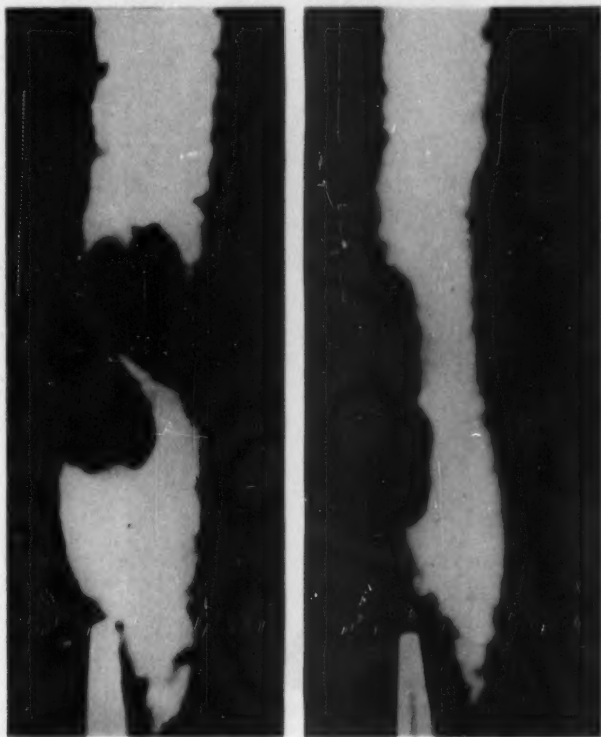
Artificially produced submucosal tumor (submucosal paraffinoma in a resected piece of jejunum). Note the sharp definition of the lesion which is indistinguishable from a lesion of the mucosa. (From Schatzki, R. and Hawes, L. E., *Am. J. Roentgenol.* 48:1-15, 1942.)
